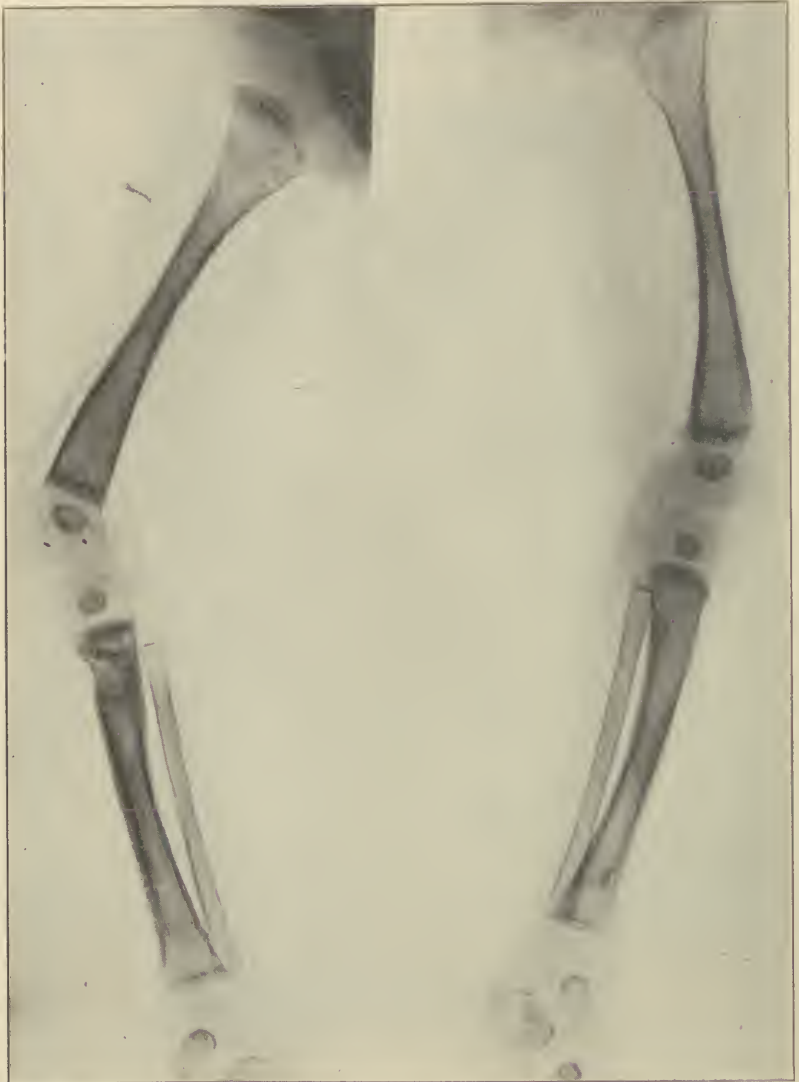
X-ray showing punched out appearance of syphilitic involvement of the bone.
